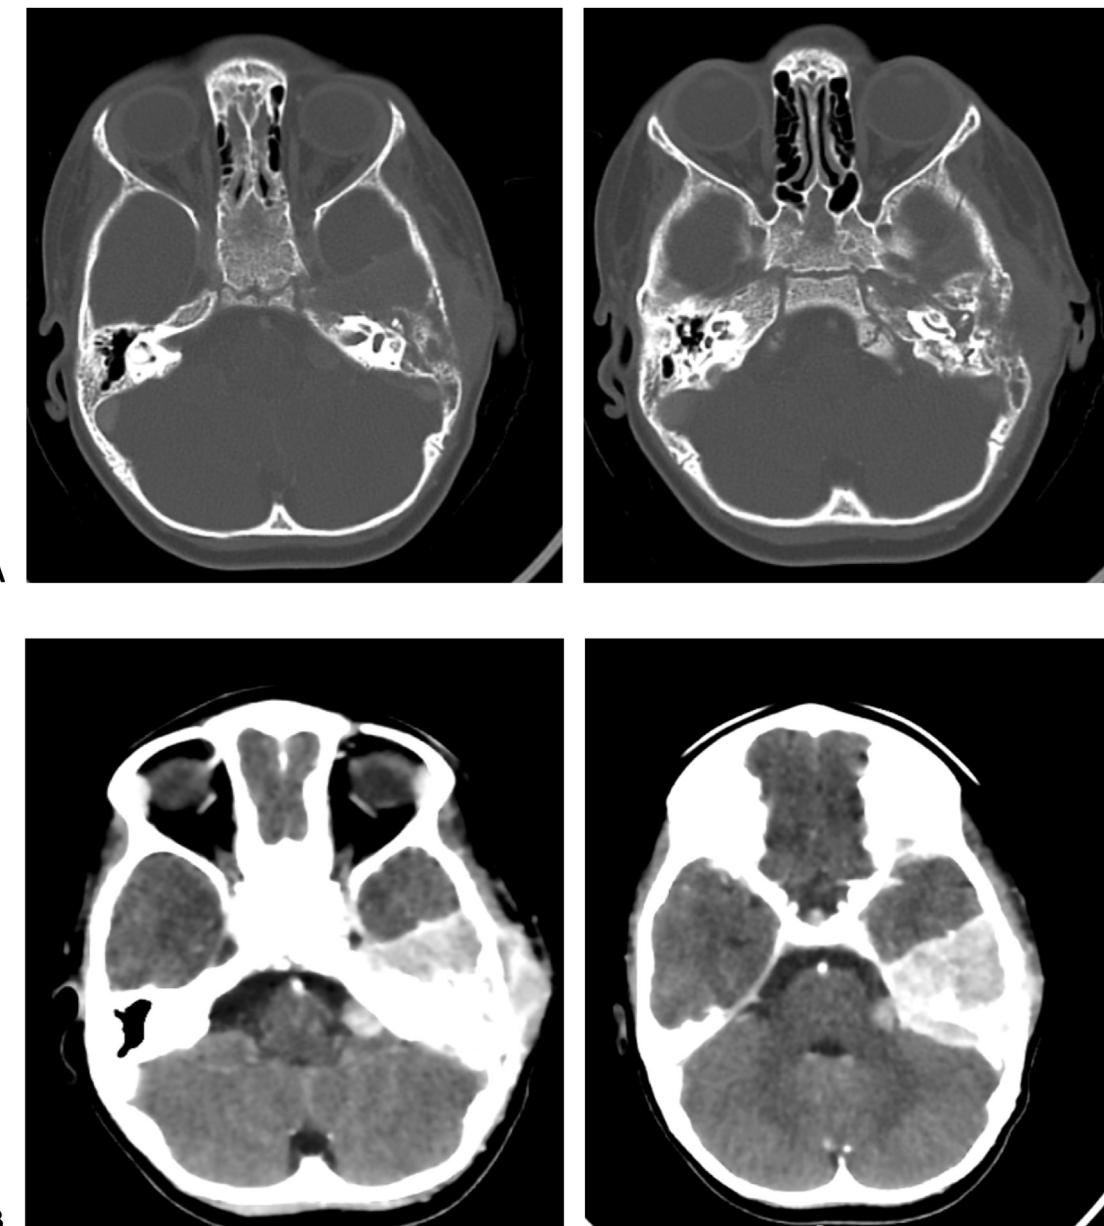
A: Axial CT scan showing bone lysis by a lesional process responsible for mastoid osteolysis with lysis of the petrous apex.
